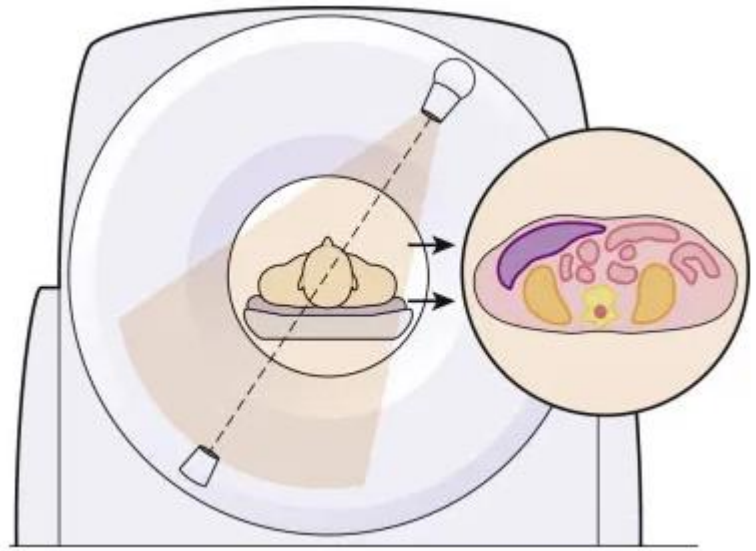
A CT image represents a cross section of the imaged subject rather than the X-ray shadow of the anatomy, as in a conventional radiograph. Source: radiologykey.com, 2019.
